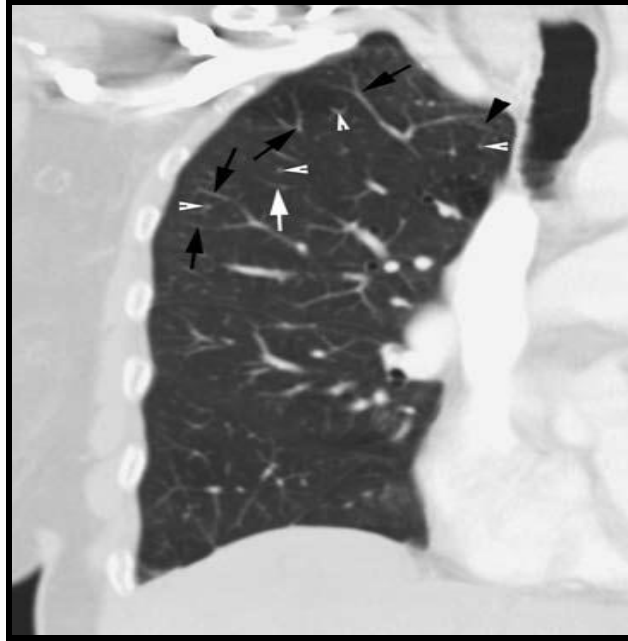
CT of the normal lung (coronal reconstruction). Interlobular septa can sometimes be recognised anteriorly and along the mediastinal surfaces (*arrowhead*) but can more often be inferred by locating septal pulmonary vein branches (*arrows*) presenting as linear, arcuate or branching structures approximately 5-10 mm from the centrilobar arteriole (*white arrowheads*) (Webb, 2006).
